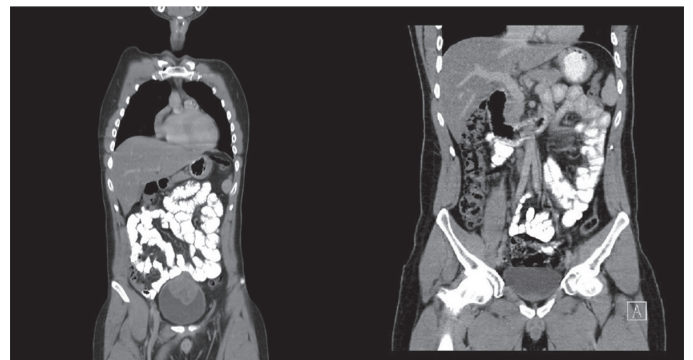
A) Contrast-enhanced computed tomography (CT) image showing a 7×6 cm mass on the lateral side and apex of the urinary bladder. B) Contrast-enhanced CT image after partial cystectomy
